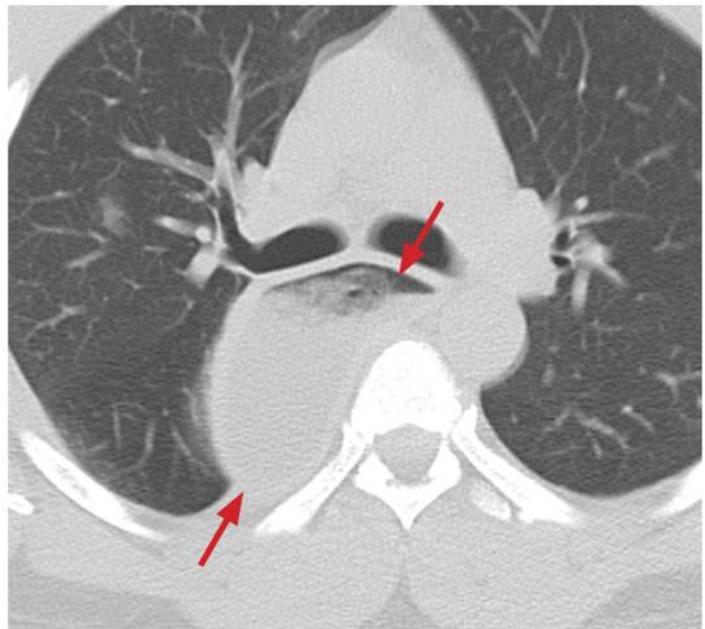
Axial non-contrast CT confirms shows a markedly dilated esophagus, and debris-filled esophagus (red arrow).¹²
